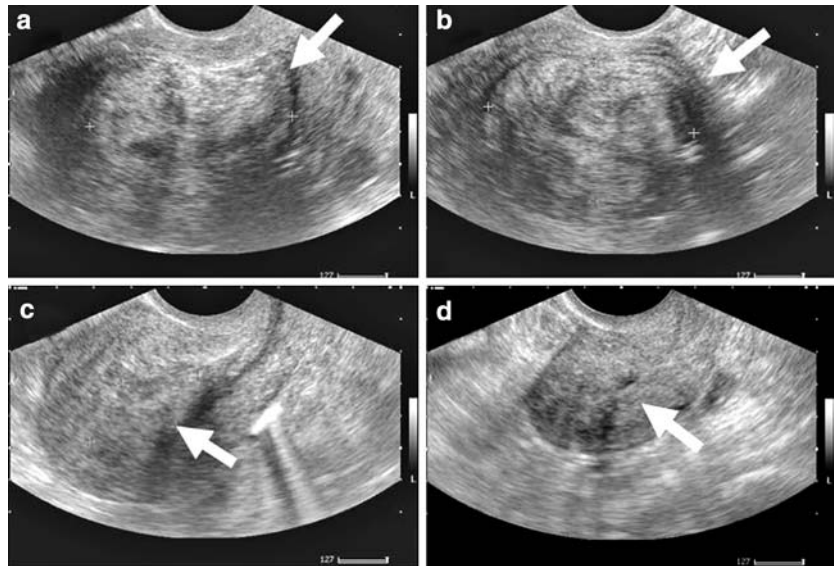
Changes on transvaginal ultrasonographic images of the submucosal myoma during the treatment course. a Submucosal myoma at the first examination. b Submucosal myoma after uterine arterial embolization. c Submucosal myoma remnant that started being expelled 12 days after hysteroscopic myomectomy. d Disappearance of remnant myoma tissue after spontaneous expulsion 3 months after hysteroscopic myomectomy
